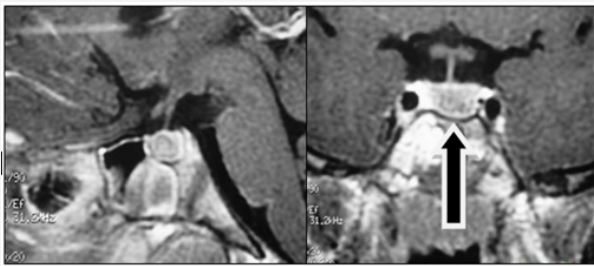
Preoperative pituitary MRI.
